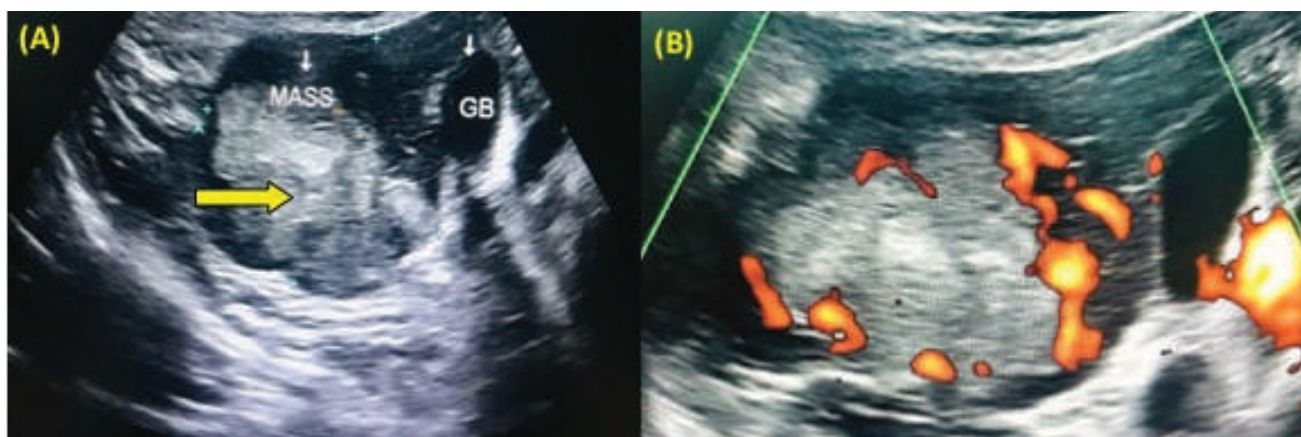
Ultrasound image of a 72 Y/O, female patient showing (A) Big heterogenous mass (yellow arrow) lesion in right lobe of liver measuring about 6.2X6.0cm. (B): Doppler flow shows increased vascularity within the mass.
